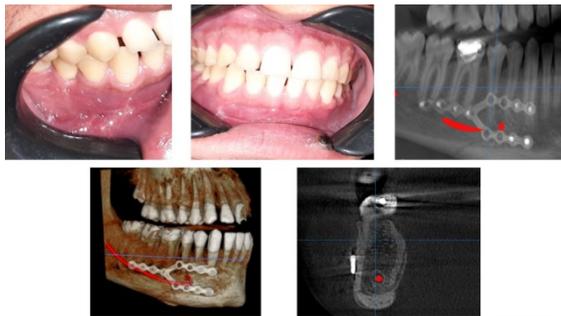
Postoperative occlusion and CBCT showing healing of the fracture
